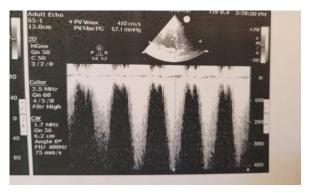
Pre-operative trans-pulmonary echo Doppler measurement showing elevated pressure gradient across the pulmonic valve consistent with pulmonary stenosis.
